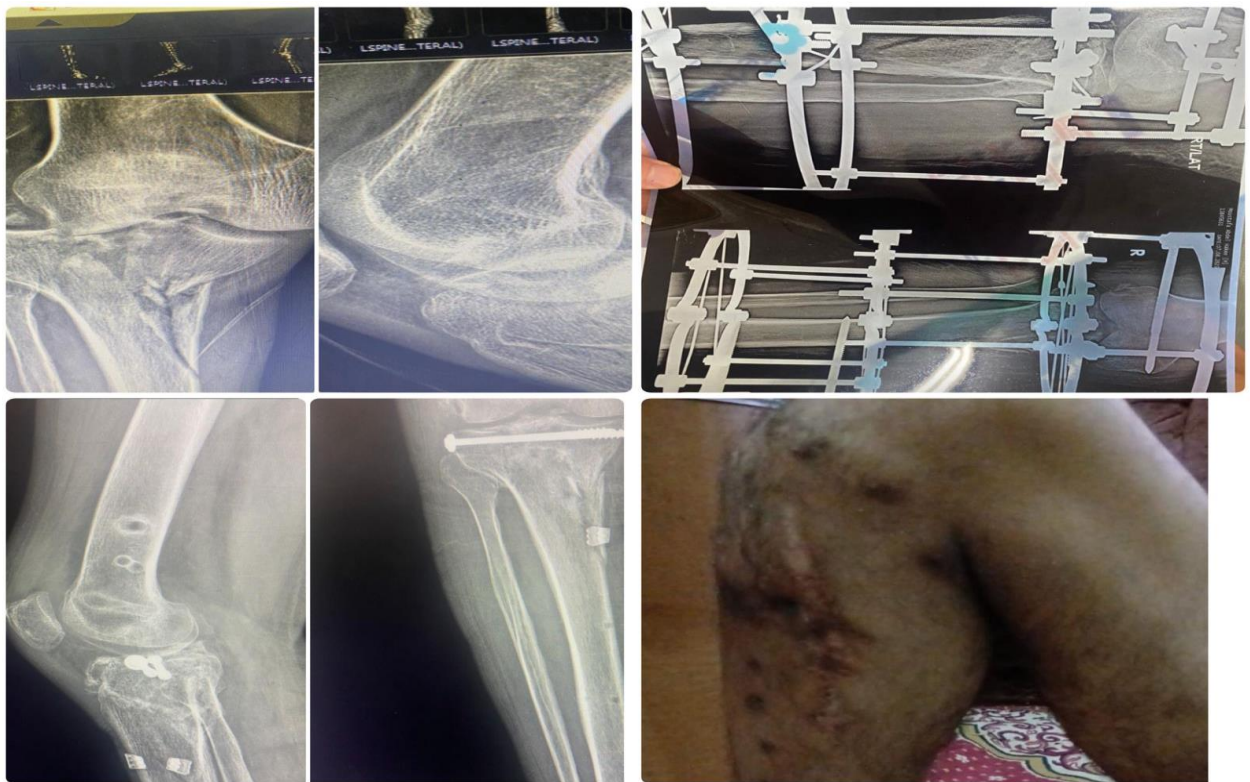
A 53-year-old male patient with rt tibial plateau fracture. showing Preoperative anteroposterior and lateral radiographs; Immediate postoperative anteroposterior and lateral radiographs; Anteroposterior and lateral radiographs at external fixator removal and Final follow-up showing ROM.
